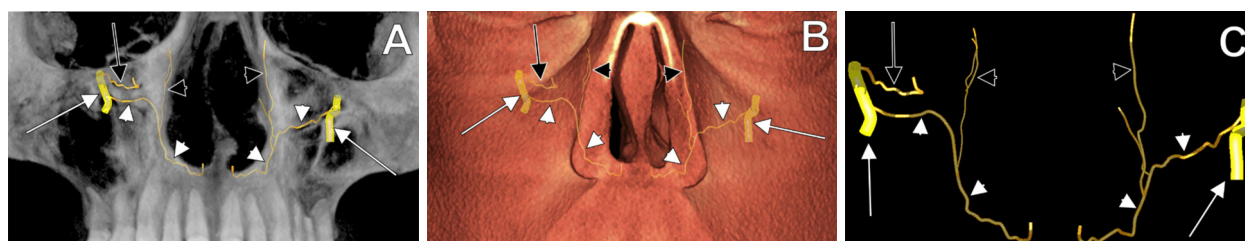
Three-dimensional volume renderizations, anterior views of the midface, Planmeca Romexis Viewer 3.5.0.R software: (A) B&W X-Ray Filter; (B) Soft Tissue Filter; (C) B&W X-Ray Filter with complete bone subtraction. There are indicated the infraorbital canals (white arrows), a left accessory infraorbital canal (black arrow), the *canalis sinuosus* (white arrowheads), and the canals of Parinaud (black arrowheads). B&W: Black & White.
